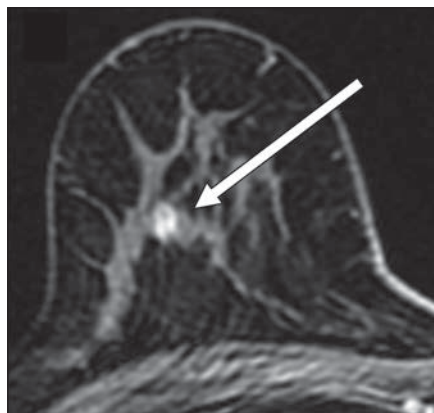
39-year-old woman at high risk for breast cancer who underwent MRI for screening.
